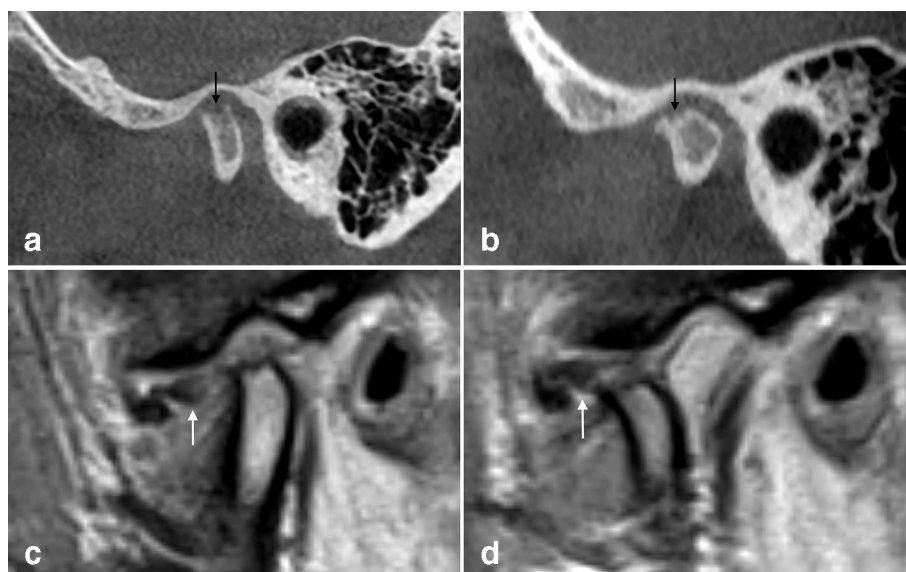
Female, 18 years at baseline (a) with 2.7 years follow-up (b). Surface destruction (arrow) (a) is replaced by irregular cortical outline (arrow) and osteophyte (b). Closed mouth MRI at baseline shows severe disc displacement; disc displaced with its intermediate zone and posterior band (white arrow) located caudally to the eminence (c) and non-reducing disc on open mouth image (white arrow) (d) The patient had been managed with counselling, masticatory muscle exercises, occlusal appliance, physical therapy, and analgesics.
